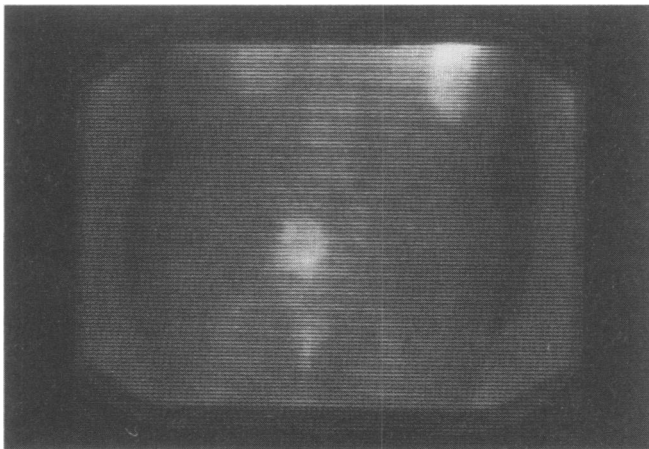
Posterior planar images, acquired 48 hours after infusion, of patient evaluated for recurrence of colorectal adenocarcinoma. The antibody scan demonstrated that the pelvic mass detected by computed tomographic and magnetic resonance imaging represented a localized recurrence. These findings were confirmed at surgery.
